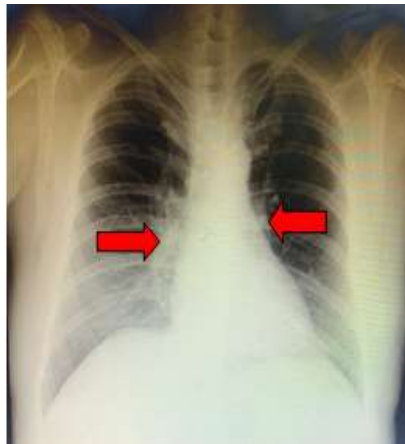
Chest X-ray of a 55-year-old male patient with positive RT-PCR for Covid-19 and had not received a vaccine injection.
